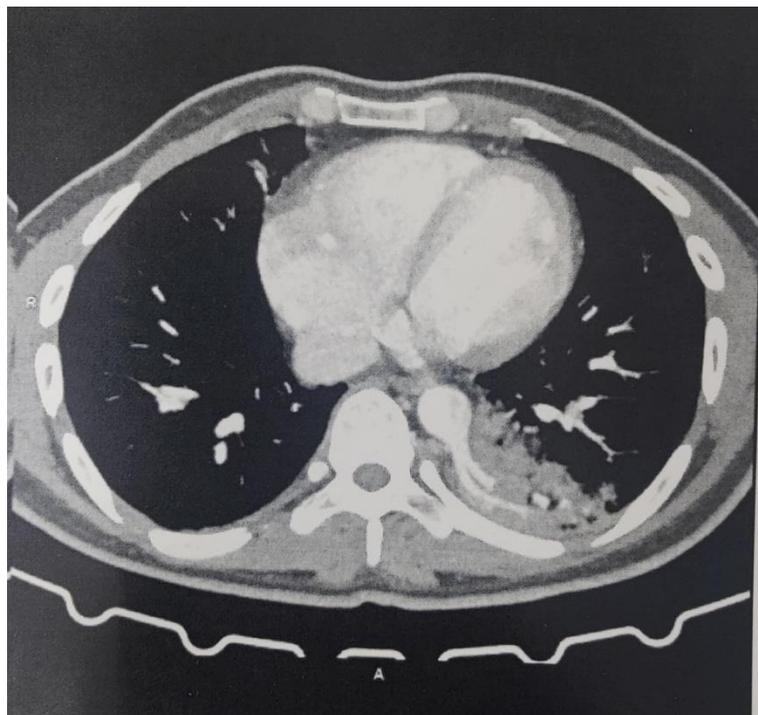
Chest computed tomographic angiography a dense and homogeneous mass in the left lower lobe irrigated by two systemic arteries
